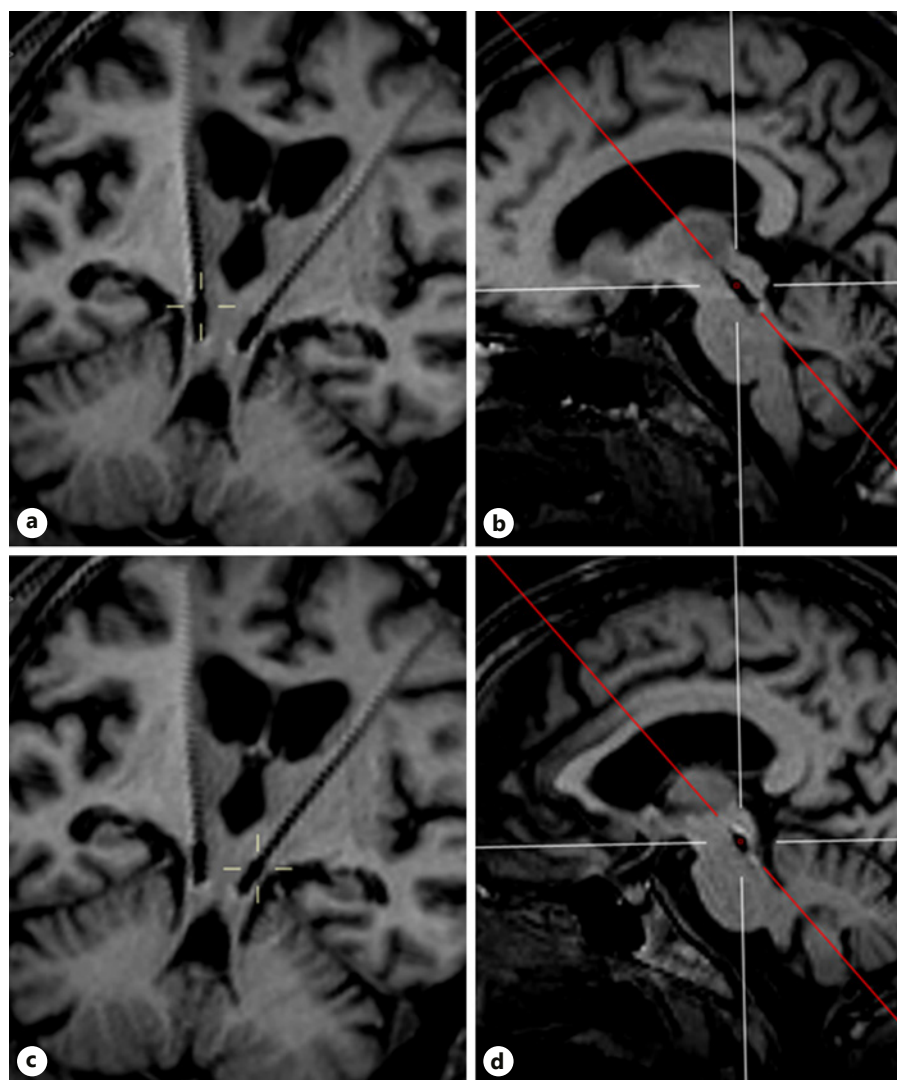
T1-weighted MR images showing trajectory of bilaterally implanted PPN electrodes in patient 6. Coronal (a, c) and corresponding sagittal (b, d) views are shown, with markers centred at the active contact location. PPN, pedunculopontine nucleus.
